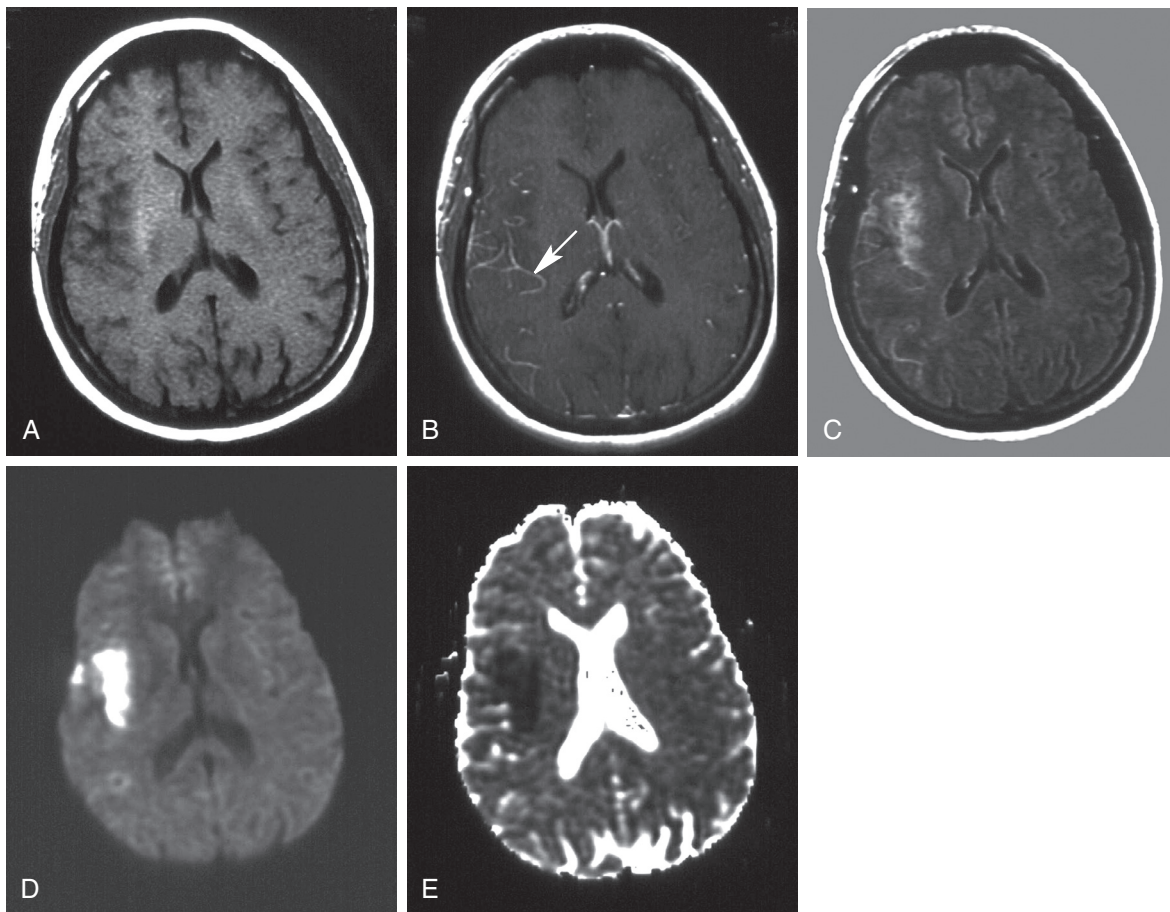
■ Hyperacute infarct. Axial T1-weighted image before (A) and after (B) contrast administration reveal subtle low-intensity and arterial enhancement (arrow) in right insular cortex. Fluid-attenuated inversion recovery (FLAIR) sequence (C) helps define area of involvement. Diffusion-weighted sequence (D) shows infarct most clearly. Acute phase is confirmed by low signal on apparent diffusion coefficient map (E).
